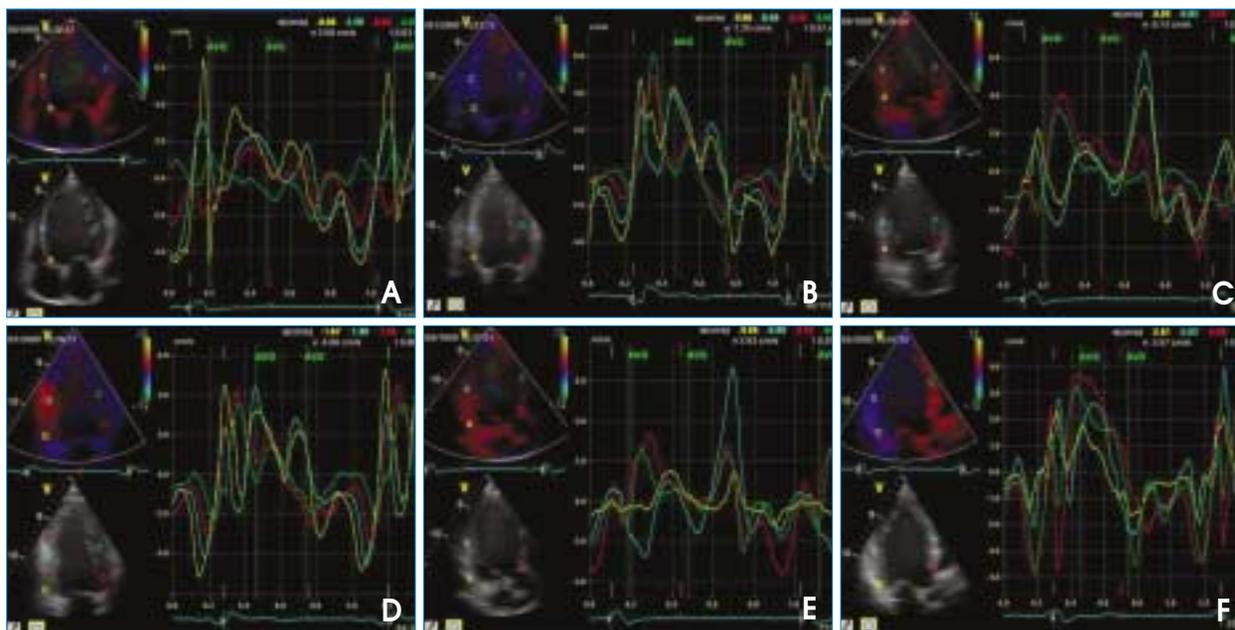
An example of myocardial velocity curves reconstituted from 2-dimensional color tissue Doppler imaging(TDI) in apical 4-chamber (A and B), apical 2-chamber (C and D) and apical long-axis (E and F) views before (A, C and E) and after (B, D and F) CRT. Multiple sampling windows are placed at both basal and mid levels. During ejection phase between the opening (AVO) and closure (AVC) of aortic valve, the time to sustained systolic peak (Ts) was measured to assess systolic asynchrony. Before CRT, this patient had severe asynchrony as reflected by the dispersion of timing to systolic peak velocity (arrows), which was significantly reduced after the therapy.
